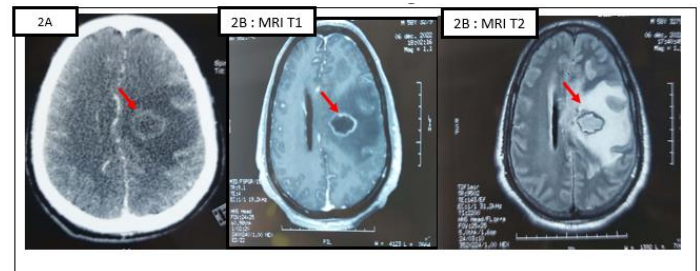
Injected brain CT-scan showing brain abscess 2B: MRI: intracranial expansive process of the left oval center in hypo signal T1 and hypersignal T2 with a restriction of the diffusion delimited by an irregular wall in hyper signal T1 and hypo signal T2 being enhanced after gadolinium injection, and measuring 27x18x27 mm. There is an important edema in glove-finger shape with a mass effect on the left ventricle and a contralateral hydrocephalus (MRI Aspect of pyogenic abscess with signs of ventriculitis and subfalcine and temporal involvement.
